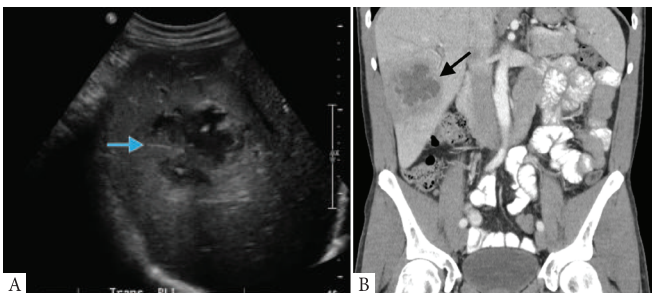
Transverse US scan through the liver: The liver abscess (arrow) shows partly ill-defined margins with anechoic (fluid-containing) areas. b. Coronal CT Image showing a liver abscess (arrow) with the typical “cluster sign”. Also note surrounding low density that represents oedematous liver parenchyma.
